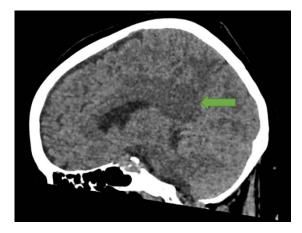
Sagittal projection of an unenhanced CT Head showing thickening and hypodensity of the corpus callosum.
